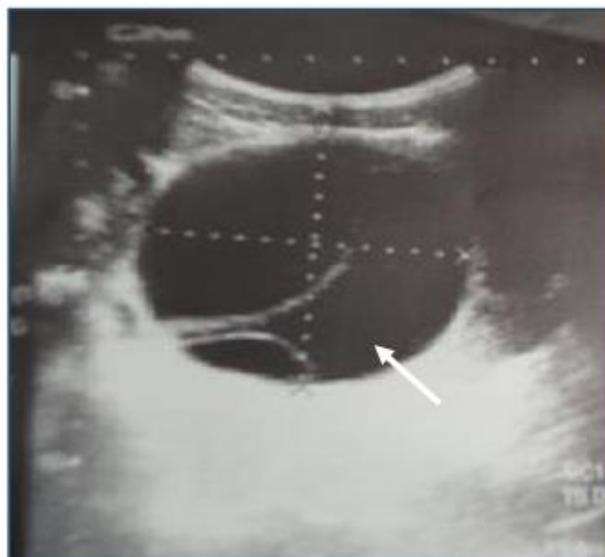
Ultrasonography of showing well defined cystic lesion in the small bowel mesentery
